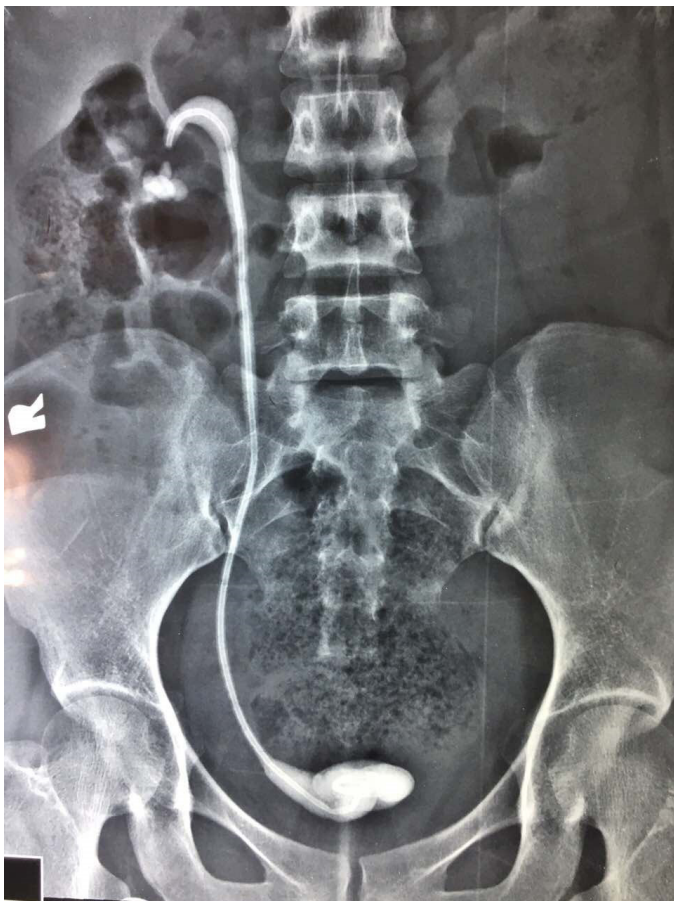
X-ray KUB showing heavy encrustations on both ends of DJ stent.
